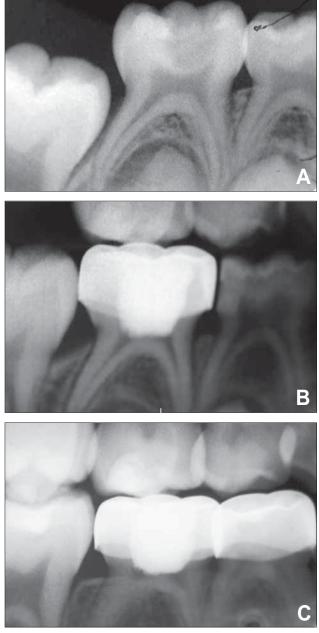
Ferric sulfate pulpotomy of tooth T. (A) Initial radiograph of T with normal radiographic findings. (B) Tooth T 10 months after treatment, with mild calcification of both mesial and distal canals. (C) Tooth T 30 months following treatment. Note significant calcific metamorphosis of both canals.
